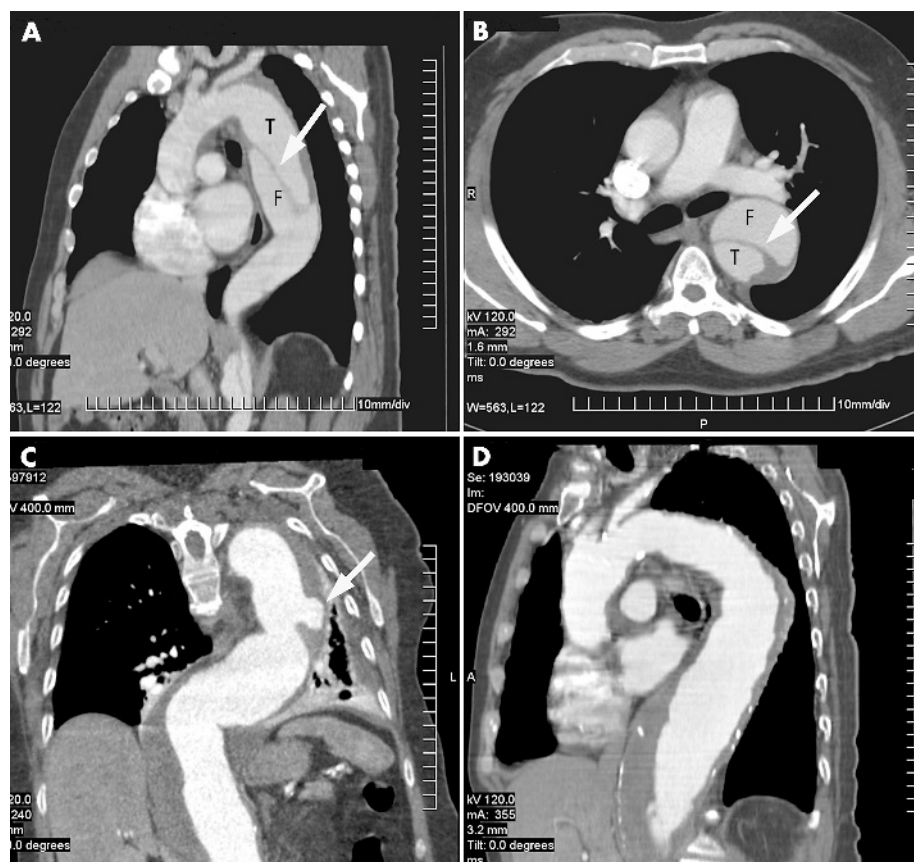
Examples of thoracic aortic pathology on CT. (A) Parasagittal image showing type B aortic dissection flap (arrow). T, true lumen, F, false lumen, LSA, left subclavian artery. (B) Axial image showing the same dissection as (A) in the descending aorta. (C) Parasagittal image of PAU in the descending aorta (arrow). (D) Parasagittal image of a descending thoracic aneurysm. Maximal diameter about 8 cm.
